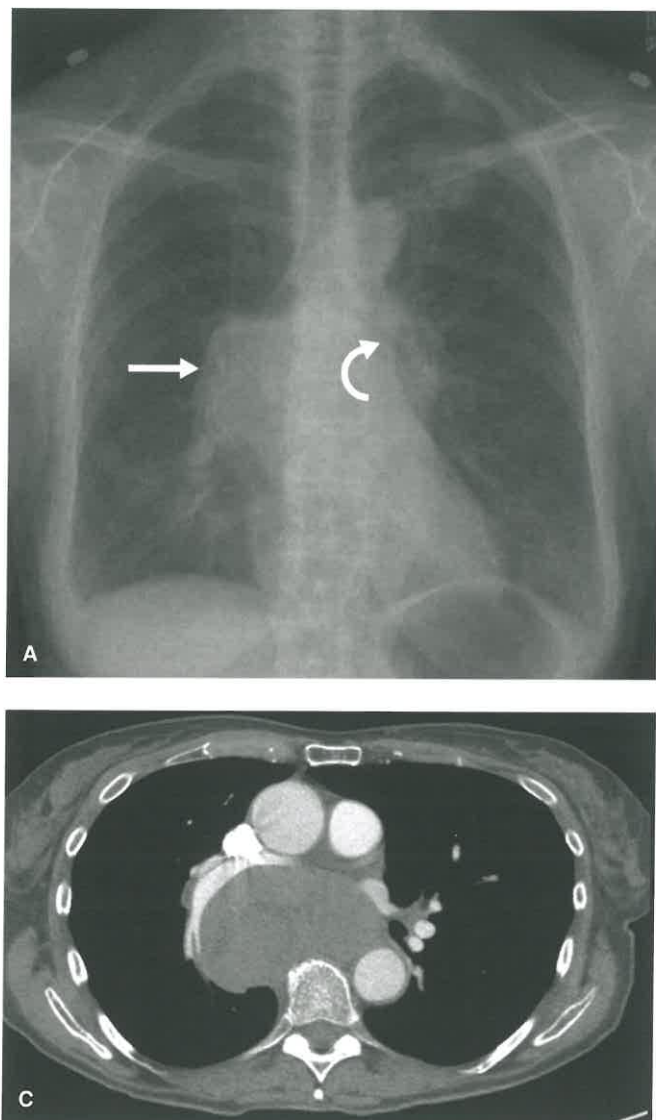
Right Hilar/Middle Mediastinal Mass due to Non-Hodgkin Lymphoma. A: Chest radiograph shows a right hilar and subcarinal mass (*arrow*). Note splaying of the carina and narrowing of the left main bronchus (*curved arrow*). The density overlying the left upper lobe is an artifact. B and C: Axial contrast-enhanced CT scans show a right hilar and subcarinal soft tissue mass. CT-guided core biopsy of the subcarinal component revealed non-Hodgkin lymphoma.
